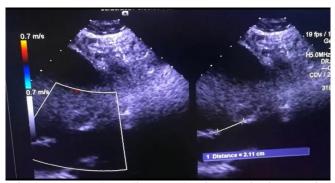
2D Echocardiogram showing an Ejection Fraction of 45% and a 22 mm measured neck of the Pseudoaneurysm
